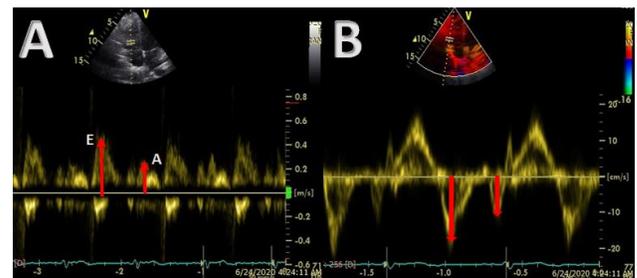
Measurement of Diastolic Functional Parameters by Pulsed Wave Doppler (A) and Tissue Doppler (B).
